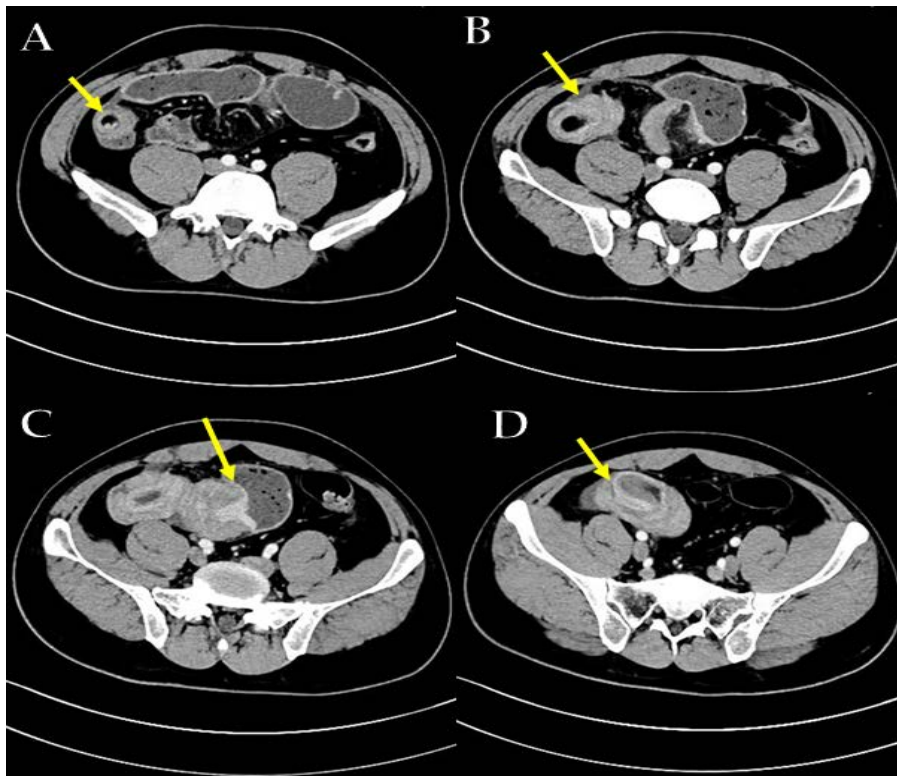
Abdominal enhanced CT showed an annular bowel shadow in the lower left abdomen, indicating the possibility of intussusception and intestinal wall thickening. A: Head of intussusception; B: distal sheath of intussusception; C: neck of intussusception; D: sheath of intussusception.
